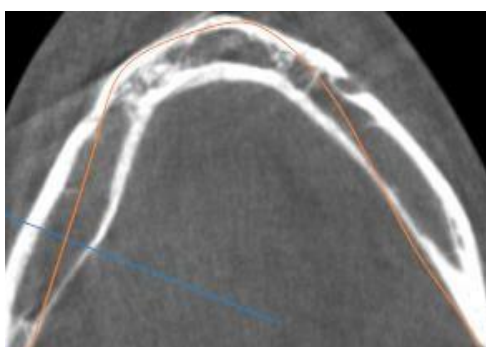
CBCT reveals radiolucency bilaterally and thinning of lingual cortices
